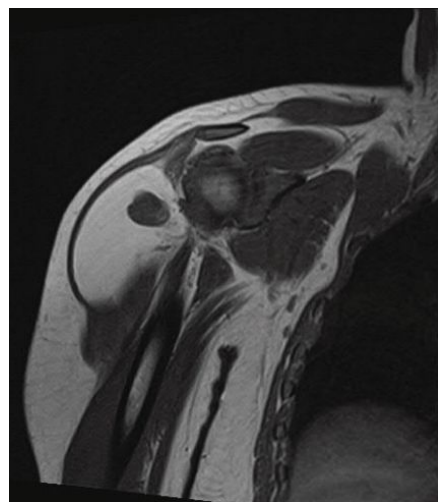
Coronal MRI of the right shoulder indicating intramuscular mass lesion within the deltoid. Mass demonstrates homogeneous macroscopic fat signal with a nodular component along the medial aspect, seen as hypointensity in T1.
